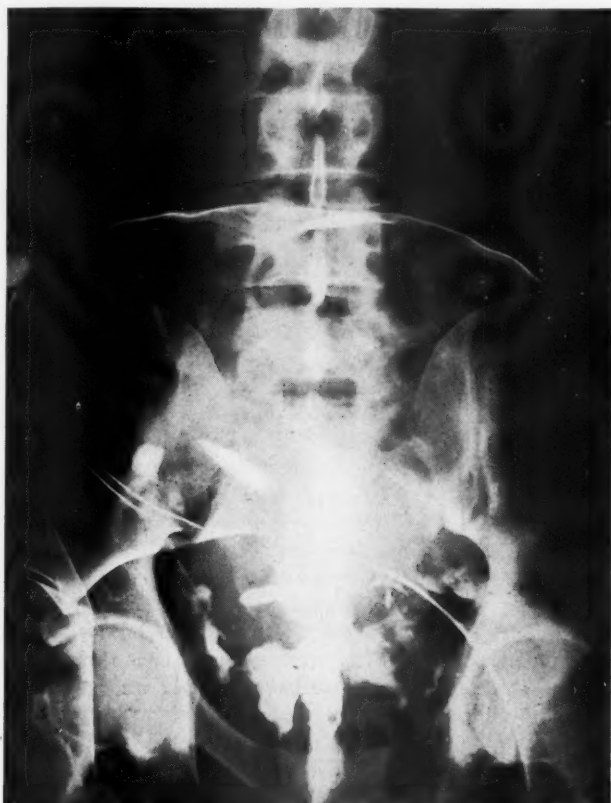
Anteroposterior radiograph after barium-filling of rectum showing the extension of barium into the infraperitoneal space and upward toward the right iliac fossa.
